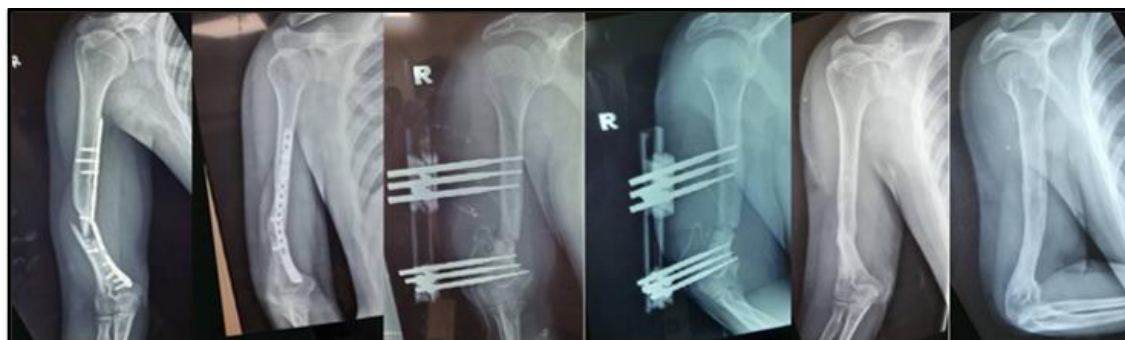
Series of X-ray from one of the patients
